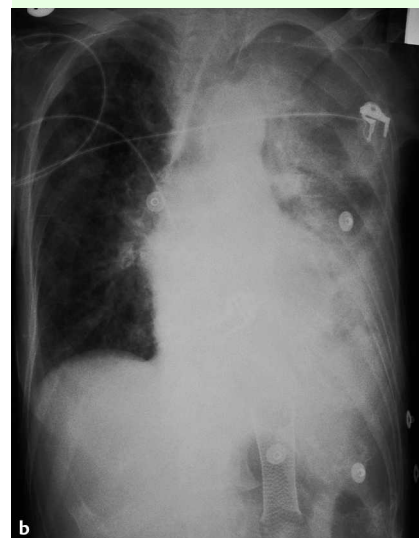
a Erect chest radiograph showing a large, multiloculated left pleural effusion. b Supine chest radiograph showing the self-expanding metallic stent.
